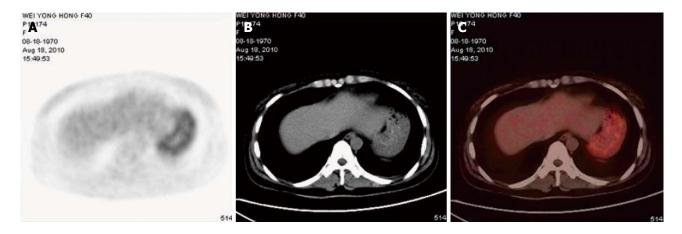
Position emission tomography/computed tomography finding. An increased 18F-FDG uptake in a diffuse manner, with a maximum standardized uptake value of 4.3 (mean 3.7) in the stomach. A: A cross-section image of position emission tomography (PET) scan; B: A cross-section image of computed tomography (CT) scan; C: PET/CT fusion image.
